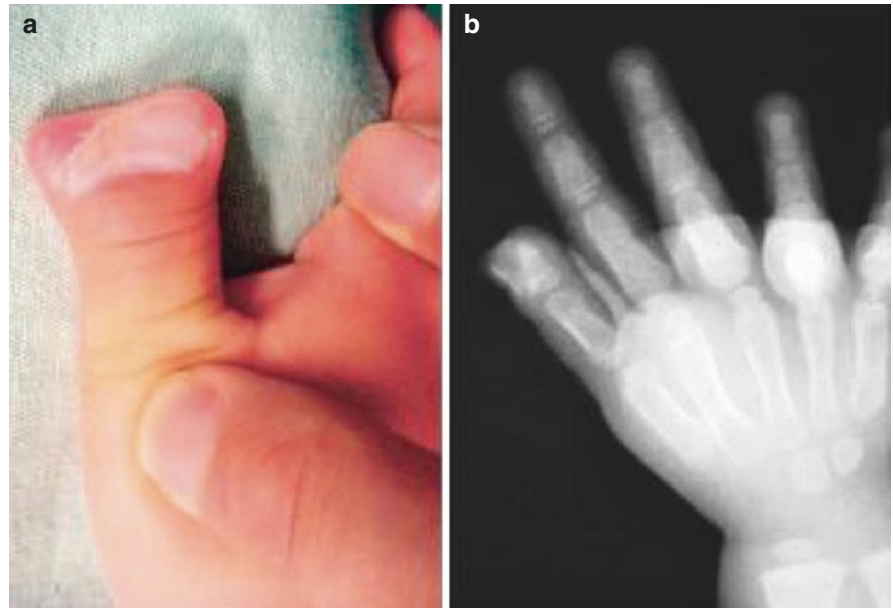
Right hand type II duplication of the thumb: the phalangettes are twin and paired, one of the interphalangeal joints are located in the central axis line of the thumb, and the other is located at the radial side of the thumb proximal phalanx. (a) Hand appearance. (b) X-ray findings
